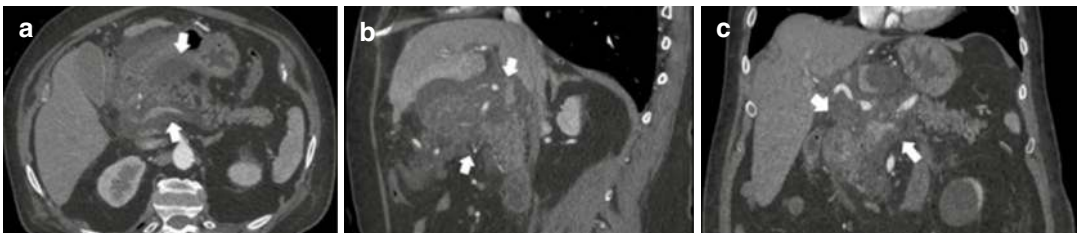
Acute necrotic collection. The contrast-enhanced CT axial scan (a) shows the presence of an acute necrotic fluid collection which involves the head and the body of the pancreatic gland (white arrows). The
